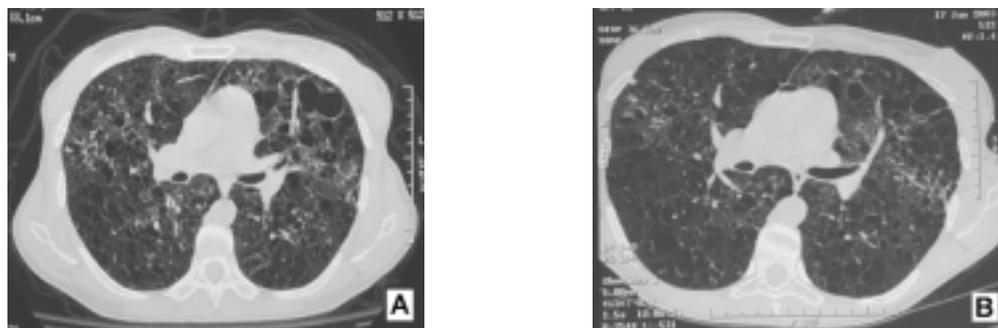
High resolution computed tomography of the lung; November 2000, at the beginning of aGnRH administration (A) and January 2003 (B), under aGnRH therapy for 2 years. Note the multiple cysts (arrow) disseminated bilateral in pulmonary parenchyma and the micronodular interstitial and trabecular hyperplasia, that worsened between 1998 and 2000, but were stable between 2000-2003.
